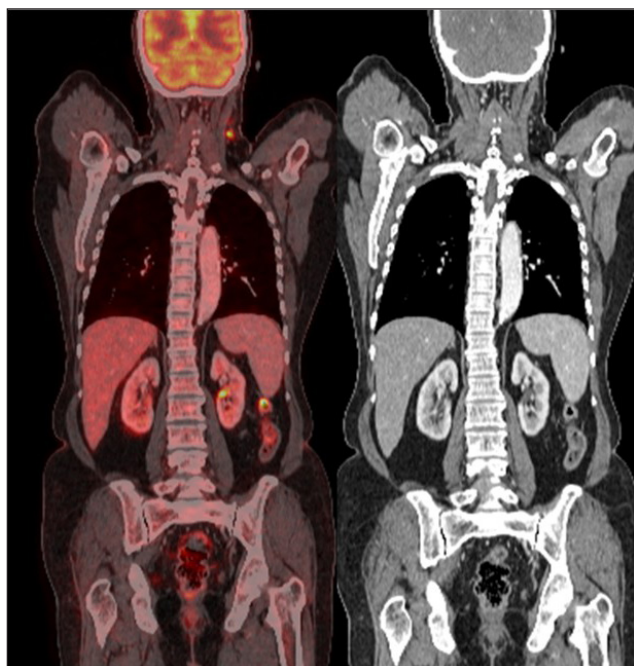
Pre treatment staging coronal PET/CT images showing normal morphology of both kidneys.
